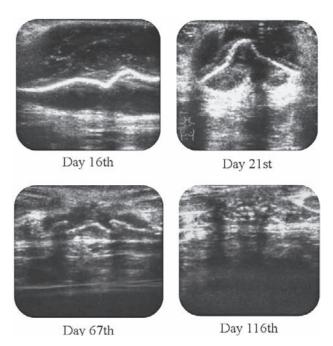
Haematoma regression monitored with ultrasound.
